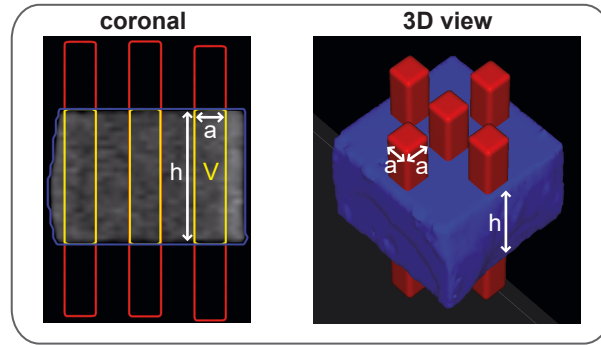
Method for the sample thickness estimation in CT images in a coronal view (left) and a 3D view (right). Well-defined matchstick-shaped volumes (shown in red) with a cross-sectional area of a^2 and their intersection volumes V (yellow) with the outer contours of the samples (blue) are used for the determination of the sample thickness h . Details are described in the text. Figure based on Behrends et al. (2022).
